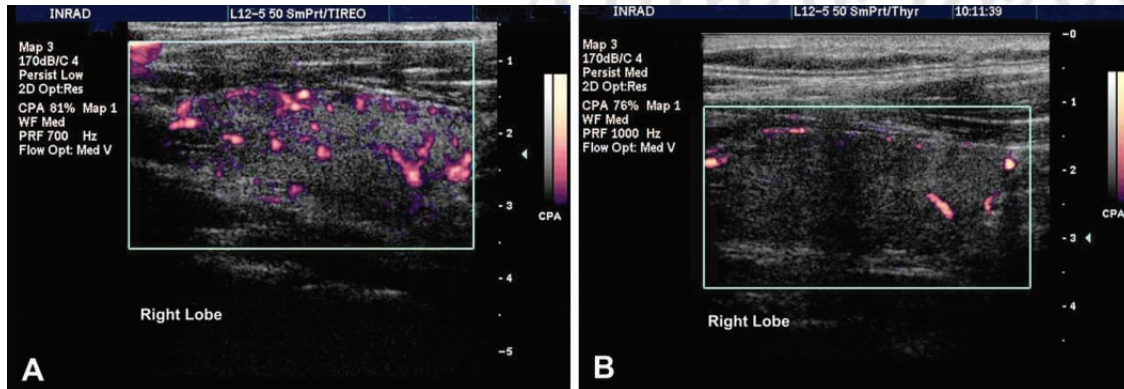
Power Doppler of the right lobe of a thyroid gland. Note the visible normalization of vascularization post-LLLT. Panel A shows increased vascularization compatible with chronic autoimmune thyroiditis pre-LLLT, whereas panel B shows normal vascularization post-LLLT.
